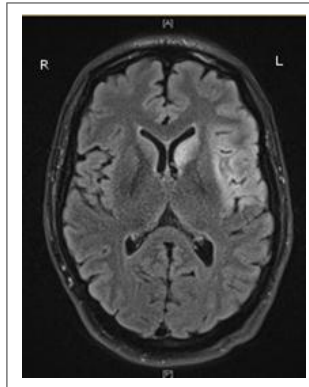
MRI-scan ten days post-stroke confirming the presence of an ischaemic lesion in the left hemisphere, encompassing the caudate nucleus, the insula and the parietal cortex. Left and right are inverted. R = right; L = left.
